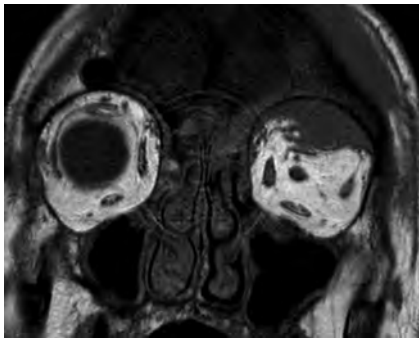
A 74-year-old man with B-cell lymphoma. Coronal precontrast T1-weighted image demonstrates lymphoma involving the superotemporal left orbit. Tumor appears to cause inferior bowing/displacement of the LR-SR band but does not definitely transgress it. Note the normal LR-SR band in the right orbit.
